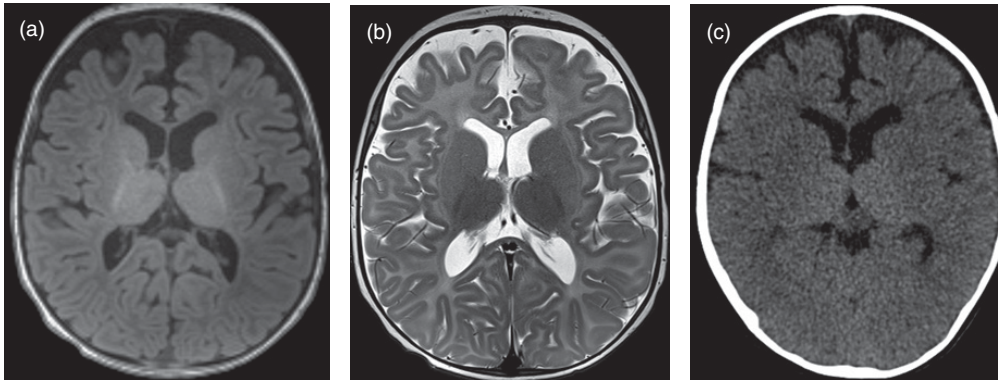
GM1 gangliosidosis in a 9-month-old infant with motor delay, hypotonia, hepatomegaly, rickets-like changes on radiographs, and cherry red spots on ophthalmological examination. (a) Axial T1 and (b) axial T2 images demonstrate a markedly delayed myelination pattern for a patient of this age. (c) There is also a question of relative T2 hypointensity of the thalami, correlating with hyperdensity of the thalami on CT, 3 months later.
